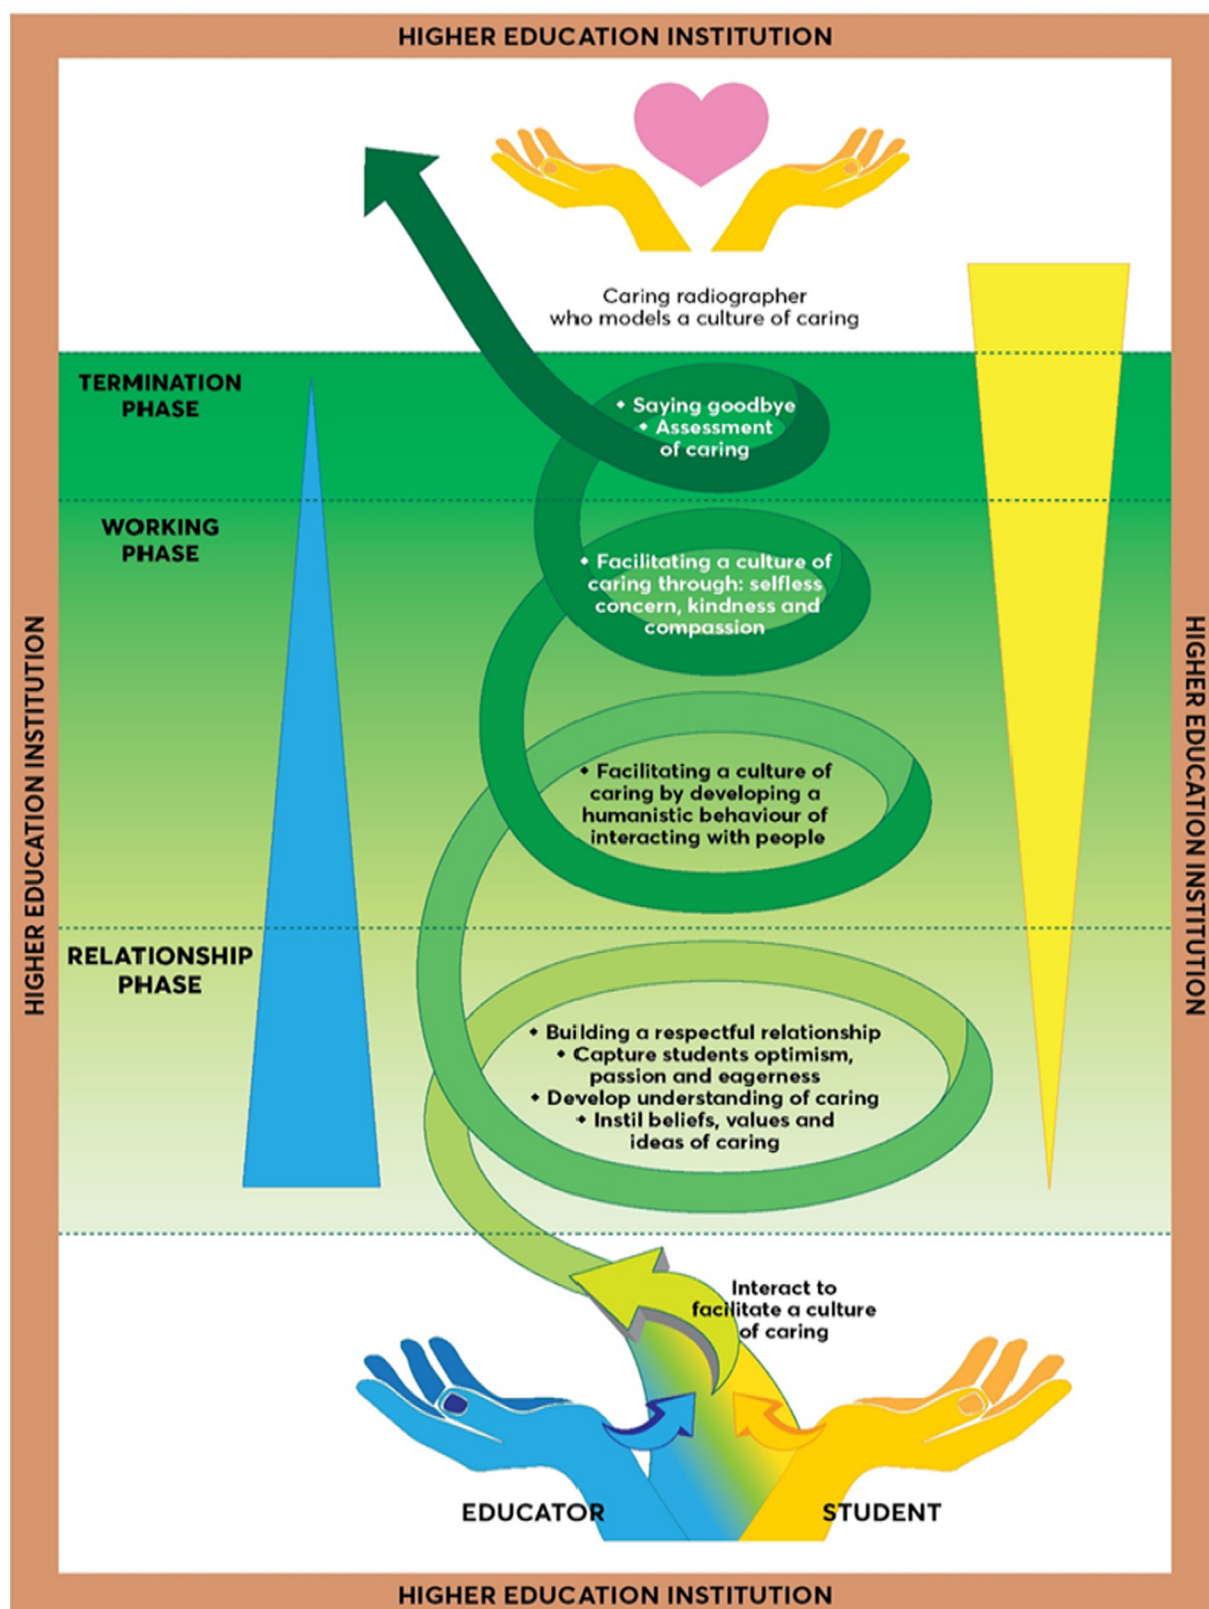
A model to facilitate the teaching of caring to first year diagnostic radiography students.
